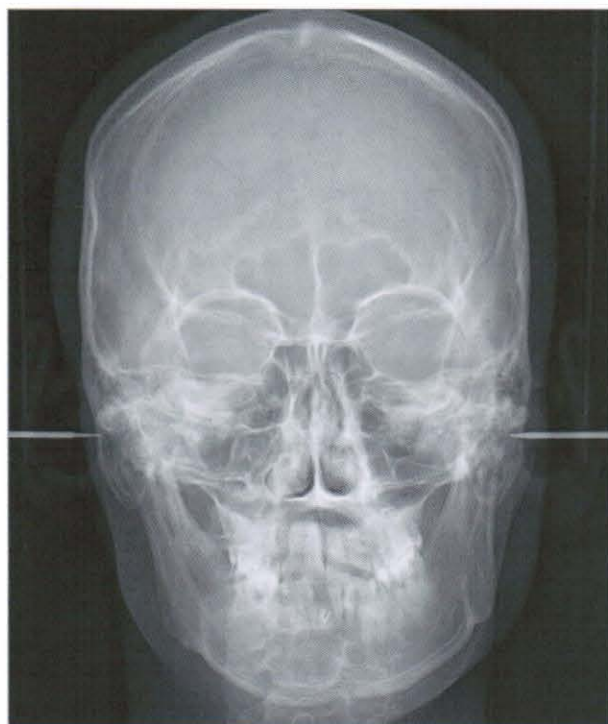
Postero-anterior radiograph. The asymmetry still remains, but the patient was happy with his dentition after orthodontic treatment and no longer complained of asymmetry.
